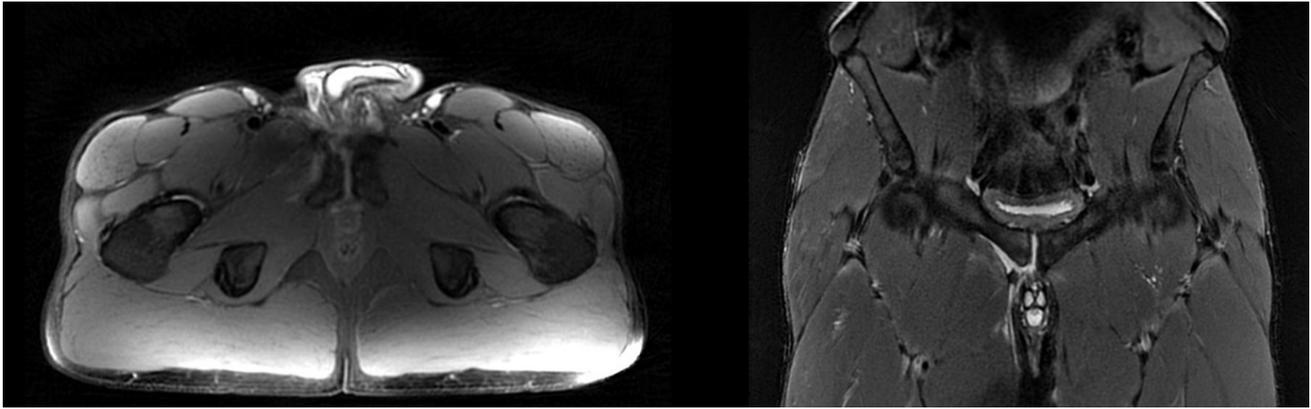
The athlete's injury viewed on MRI (axial and coronal views) 48 hours post-injury.
